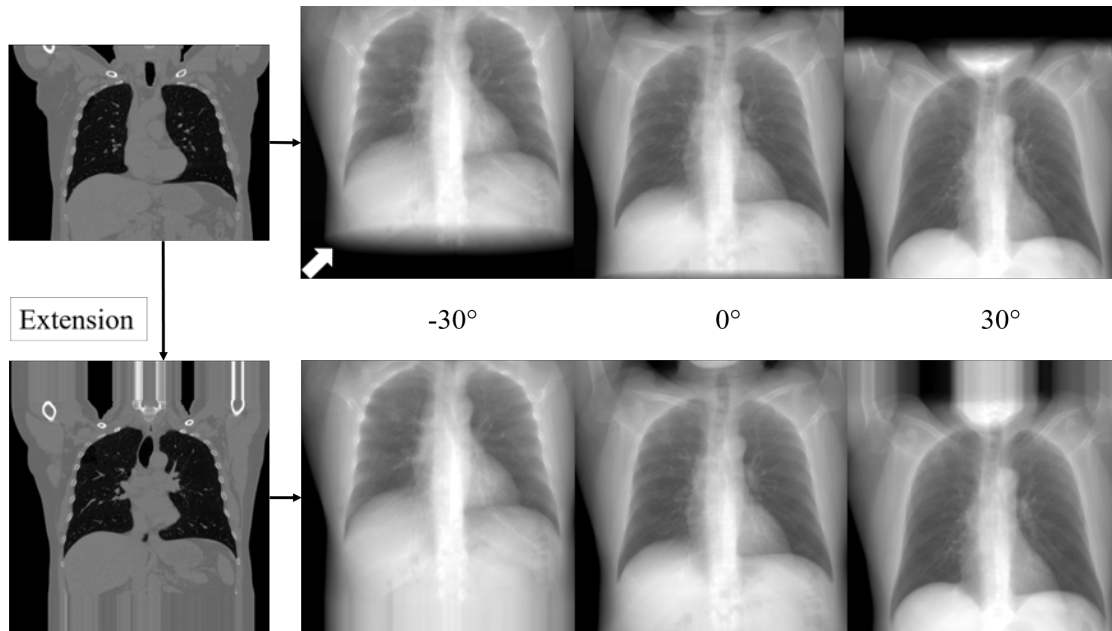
Tomosynthesis projections from CT for three different positions before (top) and after (bottom) extension. White arrow shows truncation artifact.
